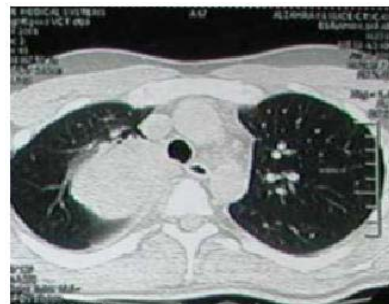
A 22-year old male presenting with back pain and dyspnea that contrast enhanced CT scan (lung window) showed a posterior mediastinal mass with RT paratracheal extension
